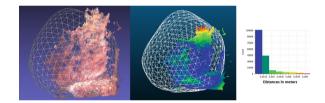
Shape registration accuracy: shown from left to right are, aligned prostate regions from stereo and MRI, points from stereo prostate shape color-mapped based on the distance to the prostate surface from MRI, and histogram showing the distribution of distances.
